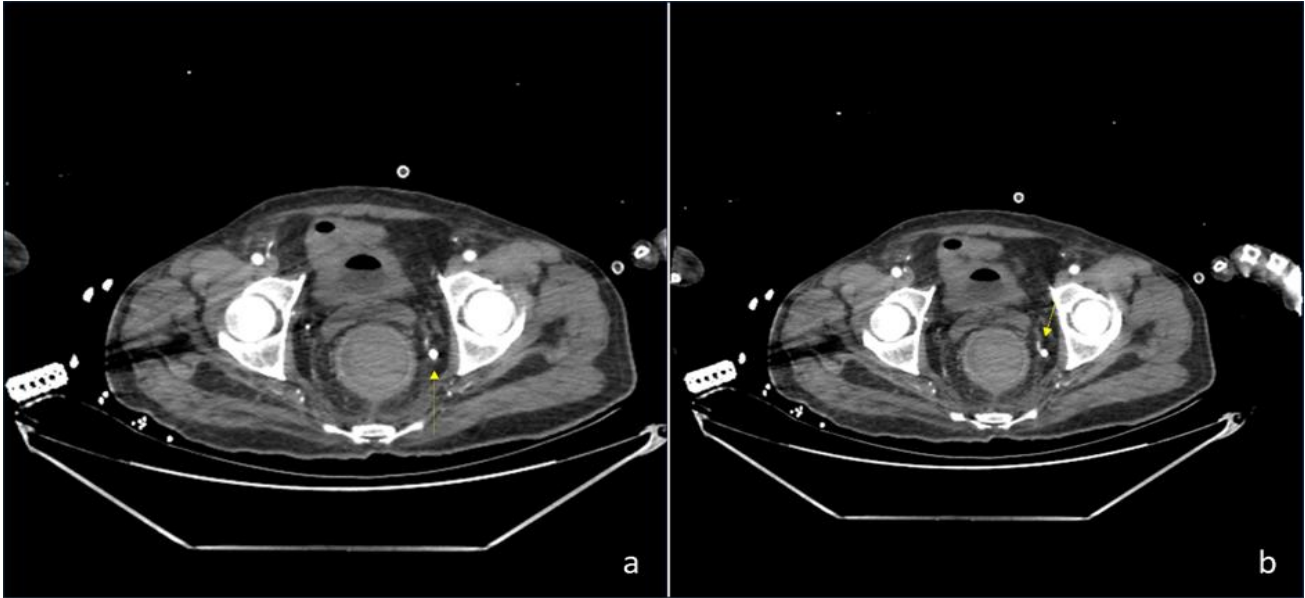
Contrast enhanced CT scan of abdomen pelvis which showed no evidence of bleed near surgical bed, instead showed: (a) bleeding aneurysm from the left inferior rectal artery and (b) active contrast extravasation from the same (marked by yellow arrows in both images).
